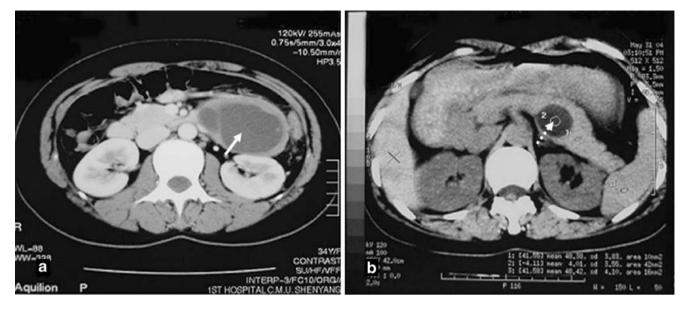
CT scan of a pancreatic mucinous cystadenoma before enucleation and after 30 months of follow-up. A Preoperative CT scan of the mucinous cystadenoma (*white arrow*) in the pancreatic body.
